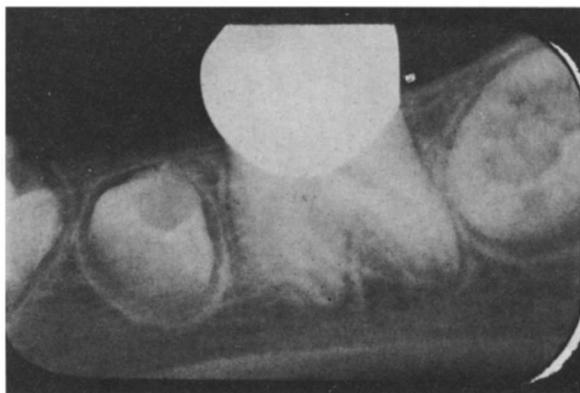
Intraoral radiograph of lower left quadrant.
